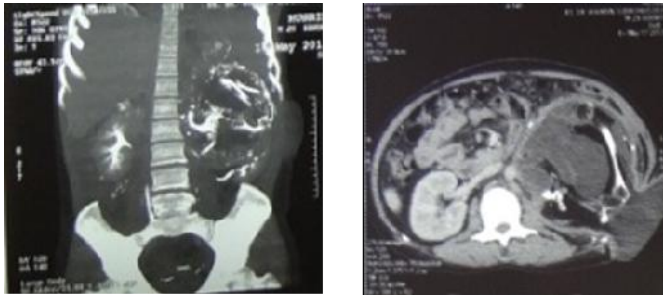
Axial and coronal view CT scan urography.
